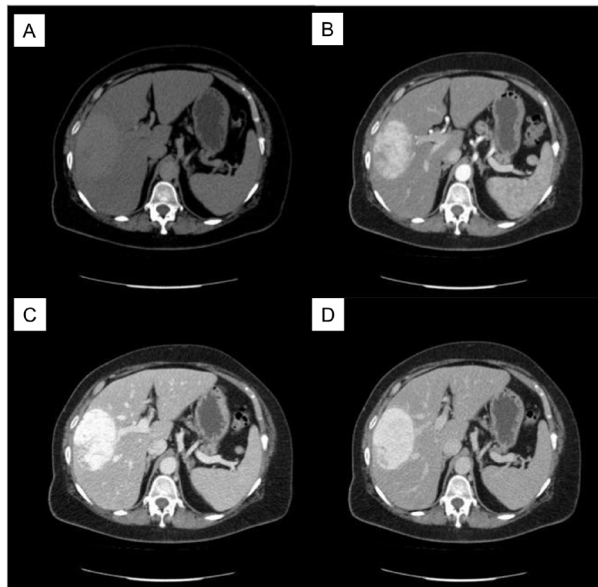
CT Scan. (A), basal phase; (B), arterial phase; (C), venous phase; (D), portal phase.
